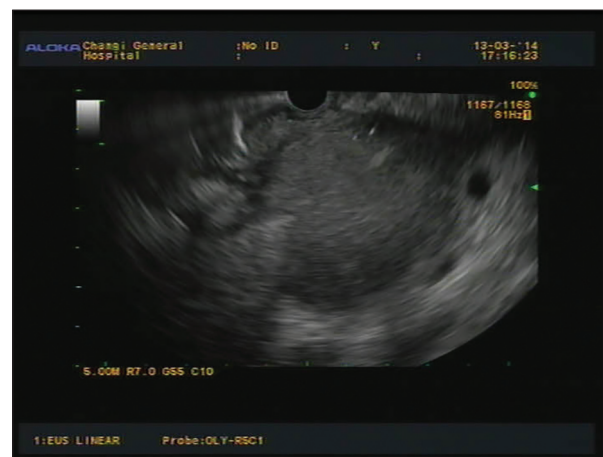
Endoscopic ultrasound image of the infected collection
